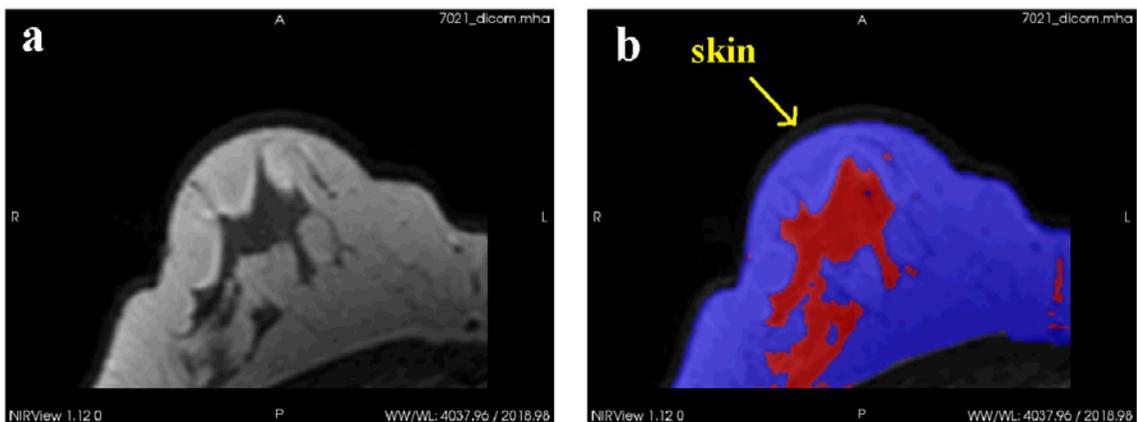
(a) Original MRI axial slice of the breast, (b) same axial slice of the breast with the glandular and other breast tissue segmented in red and blue respectively; MR breast skin extraction has allowed the skin to be separated from other tissue types, and removed from the segmentation.
